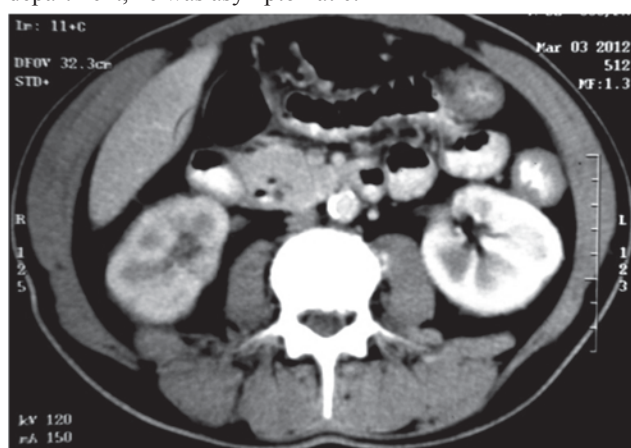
CT abdomen (on 30th day) showing improved findings of the right kidney.
